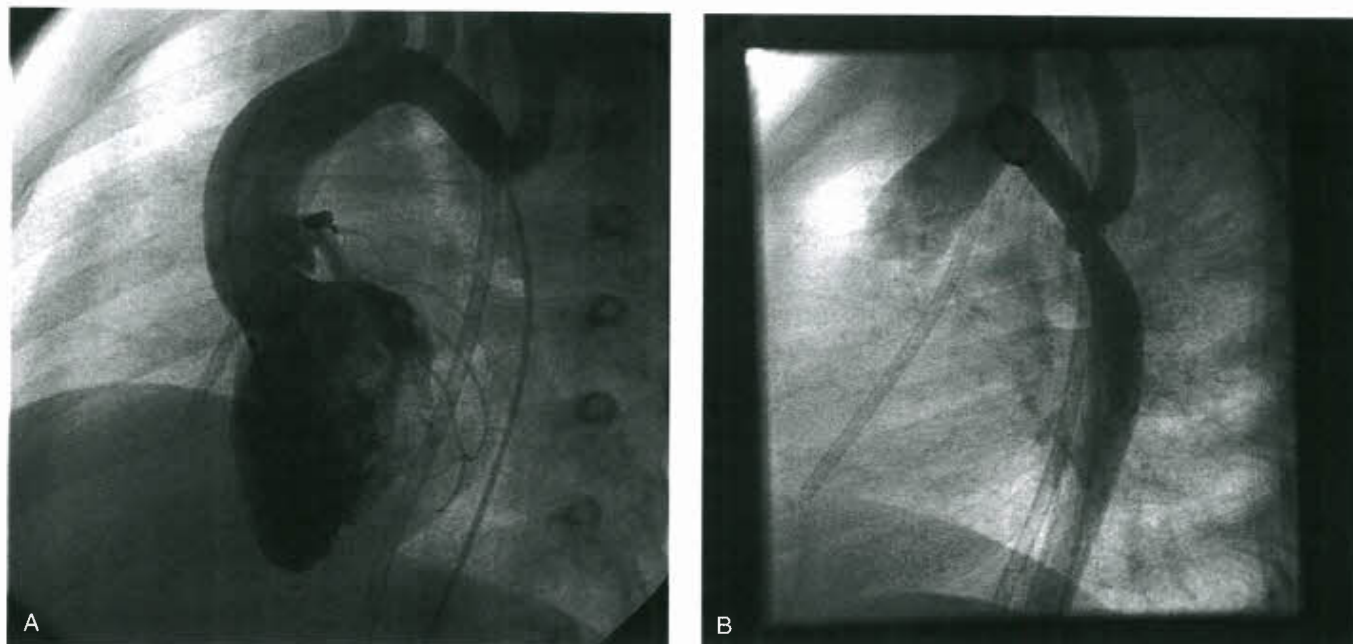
Angiograms in the lateral projection before (A) and immediately after (B) balloon angioplasty of a native coarctation in a 3-year-old girl. Prior to angioplasty (A) there is a severe discrete coarctation completely occluded by the catheter. Immediately after angioplasty (B), the aortogram documents improvement in the stenosis, with an intimal irregularity anteriorly. Two years later, CT angiography documented an excellent anatomic outcome without aneurysm. There was no residual pressure gradient in follow-up.
